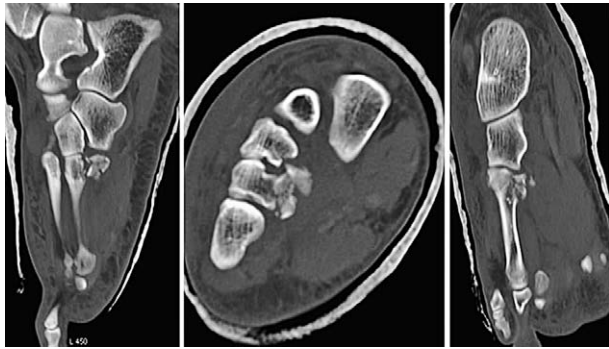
Computed tomographic images of the foot after reduction and casting. Reduction of the cuboid bone and fracture of the basis of the fourth metatarsal bone are seen.
